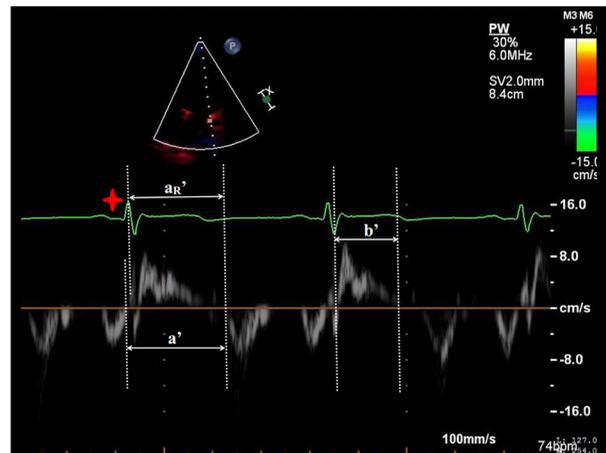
Doppler ultrasound mapping of the motion of the cardiac mitral valve annulus and the R-wave modified tissue Doppler imaging myocardial performance index (MPI TDI-R). The volume of the left ventricle (LV) free wall. The mitral valve flow spectrum includes the time interval of the endpoint of peak A to the onset of peak E, which is measured and defined as the time interval, which includes isovolumetric contraction time (ICT), ejection time (ET) and isovolumetric relaxation time (IRT). The myocardial performance index (MPI) = $(ICT+IRT)/ET = (a-b)/b$. The R-wave modified tissue Doppler imaging (TDI) myocardial performance index (MPI) or MPI TDI-R = $(aR-b)/b$. TDI – tissue Doppler imaging; MPI – myocardial performance index; LV – left ventricle; ICT – isovolumetric contraction time; ET – ejection time; MPI TDI – tissue Doppler imaging myocardial performance index; MPI TDI-R – R-wave modified tissue Doppler imaging myocardial performance index.
